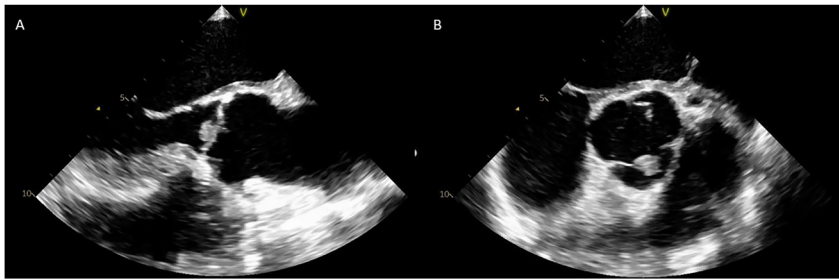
The patient's transesophageal echocardiogram from long (A) and short (B) axis views showed a spherical, shimmering, echodensity on the aortic valve.
